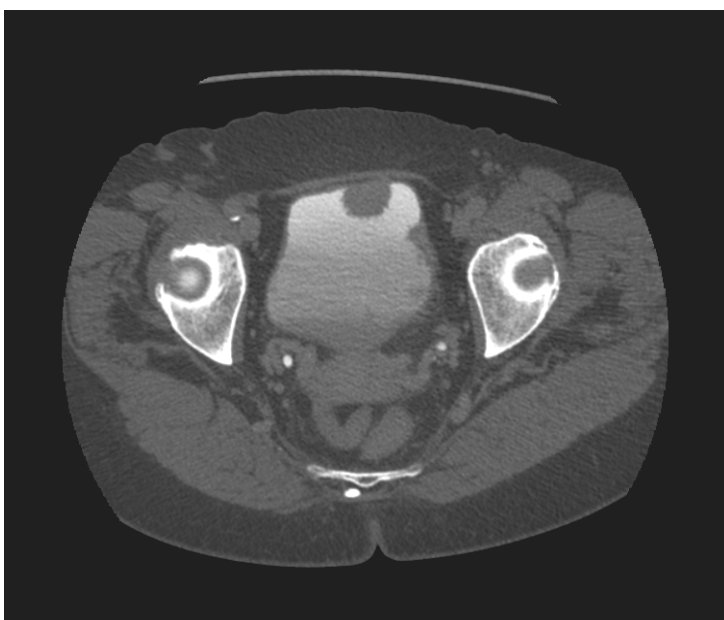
Following exercising including rolling on the CT table a large anterior wall bladder cancer is now demonstrated.
